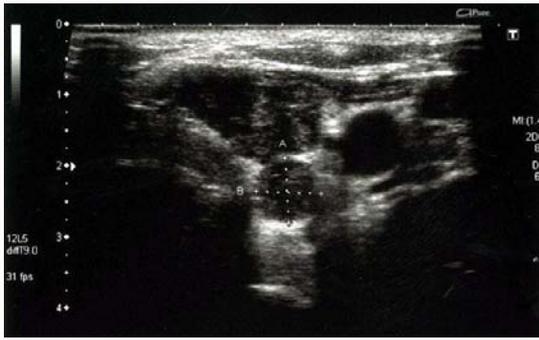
Neck ultrasonographic findings.
